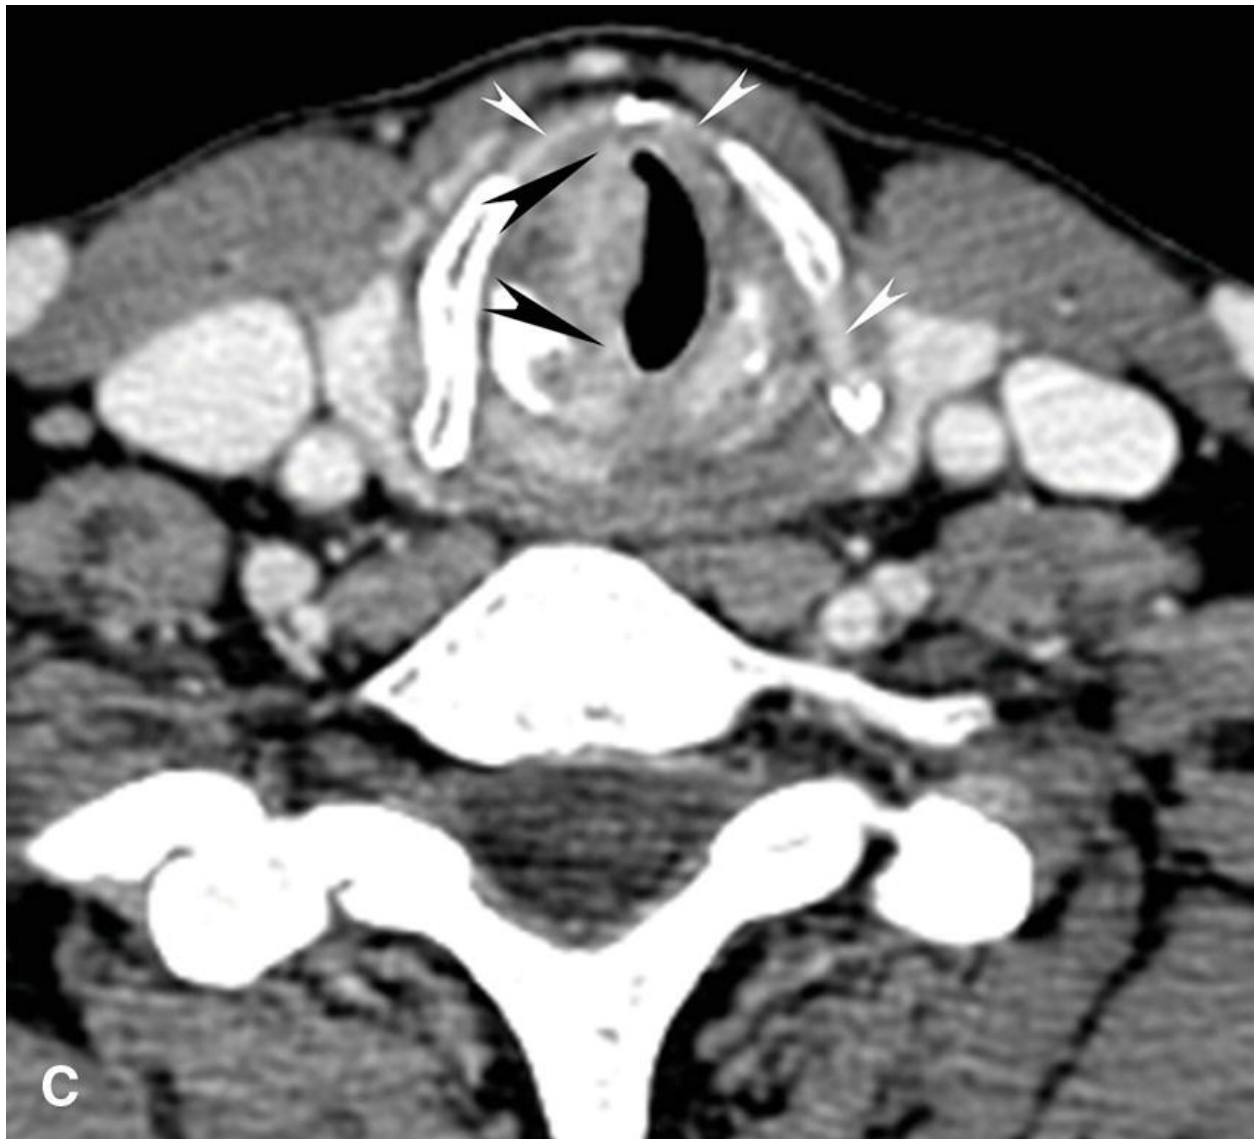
SCC of the larynx. Axial CT image from a 57-year-old woman
